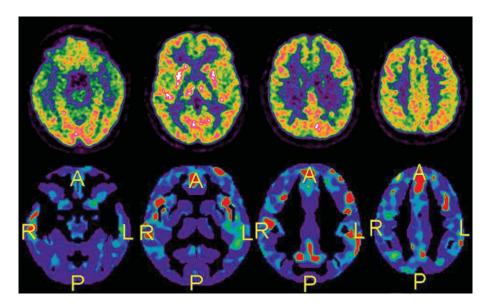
Example of false positive reading with the moderately-skilled readers. The AD hypometabolic pattern was erroneously recognized by the moderately-skilled readers in a 62 year-old male control subject with a normal PALZ score (T-sum within AD regions: 8,044). On top, FDG-PET visual analysis discloses very mild and sparse asymmetries in frontal-insular and inferior parietal regions (left minus) and in superior parietal region (right minus) (higher to lower uptake in white, red, yellow, green, and blue colors in decreasing order). On bottom, statistical maps obtained by means of the PMOD software showing very small and sparse significant hypometabolic clusters (in red).
